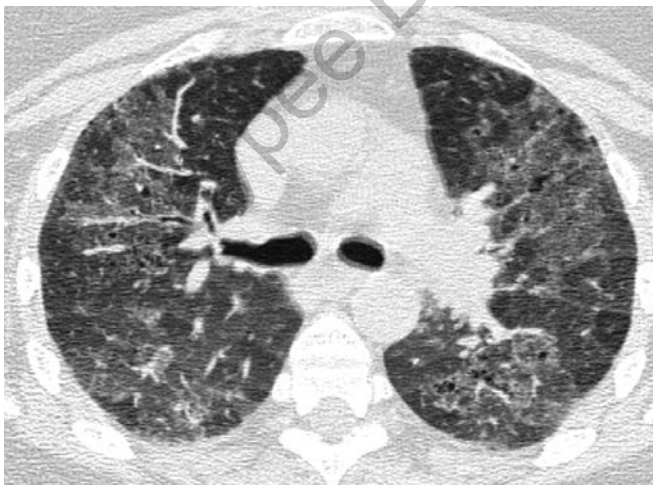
CT chest through the upper lobes in a patient with desquamative interstitial pneumonitis showing a diffuse ground-glass attenuation
